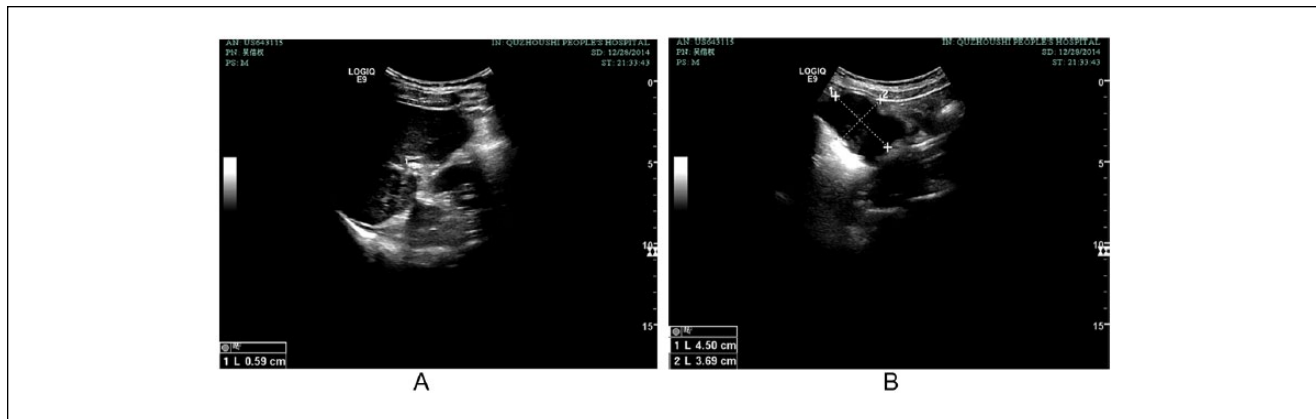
Ultrasonography of liver and omentum metastasis with TCM treatment on December 28, 2014. (A) Recurrent tumor in liver disappeared. (B) Omentum metastasis measuring 4.5 cm × 3.7 cm.
